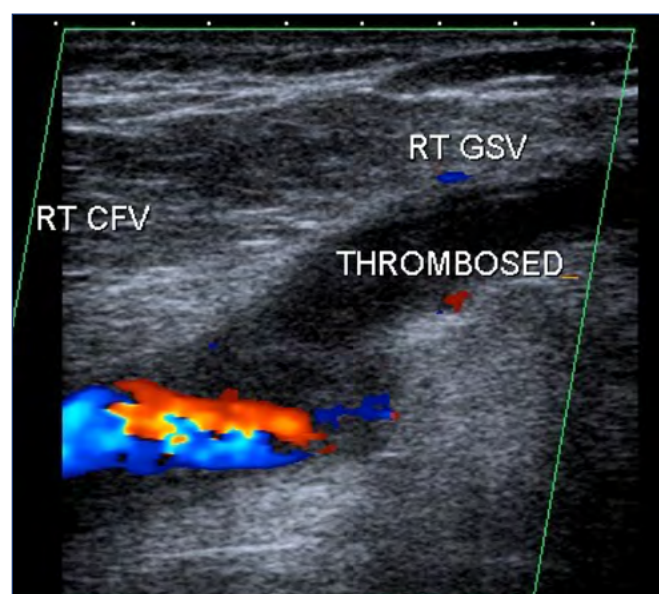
Longitudinal ultrasound image demonstrating color flow in the main section of the right common femoral vein (RT CFV) and thrombosis extending from the right greater saphenous vein (RT GSV) just into the CFV.
